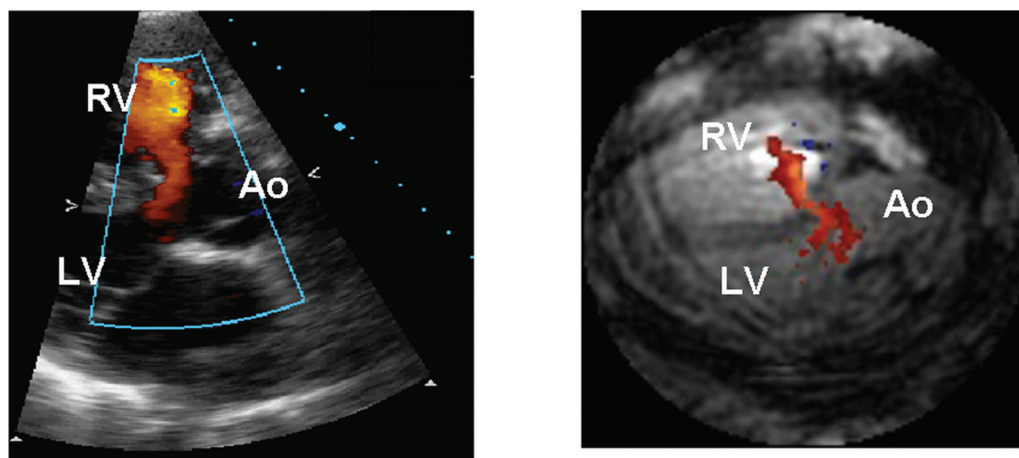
Perimembranous VSD. A color-flow jet without significant aliasing is seen going from left-to-right across the ventricular septum on both echocardiography (left) and color-flow CMR (right). Ao-aorta. Supplemental material is available for this figure. Go to the publisher's online edition of *JCMR* for the right image as a movie.
